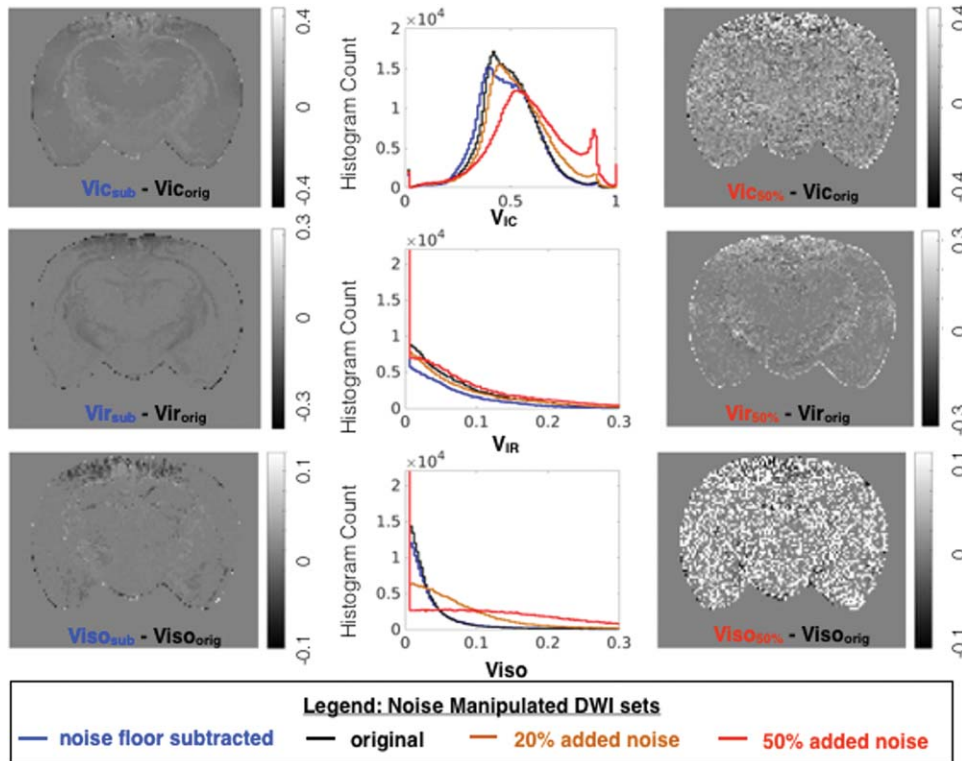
Effects of signal transformation and added noise for metric maps for compartmental fractions from the NODDI model. For each metric, whole brain histograms are shown for modeling of the original DWI dataset (black) and of the same dataset following noise floor subtraction (blue), addition of 20% or 50% rectified noise (orange and red, respectively). To visualize the localization of metric differences resulting from noise manipulation, difference maps are shown for the same slice.
